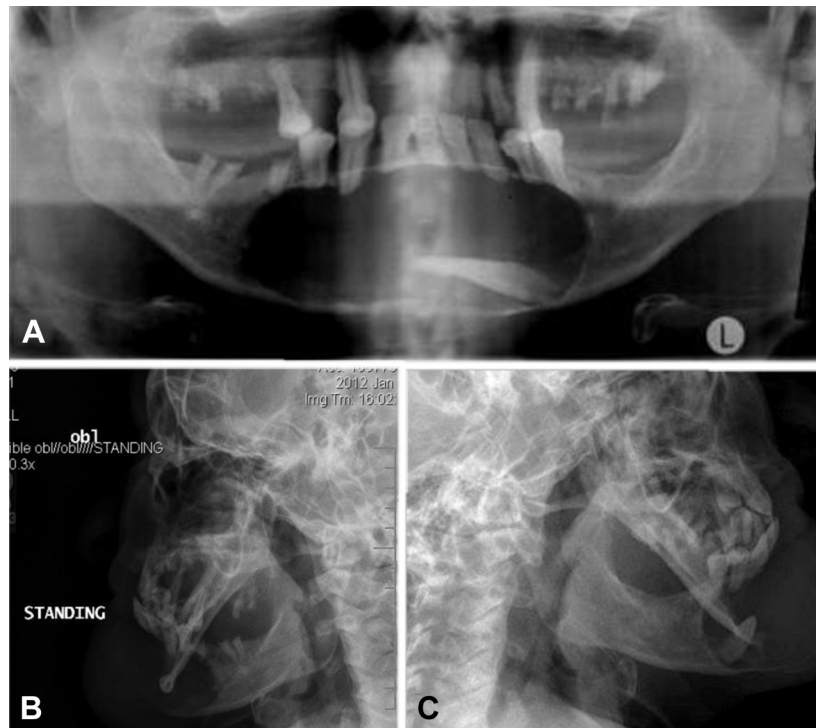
A, Massive, well-demarcated, unilocular radiolucency of the anterior mandible associated with an impacted cuspid. It demonstrates severe root resorption and tooth displacement. B, C, Lateral oblique jaw radiographs help orient the position of the impacted tooth.
